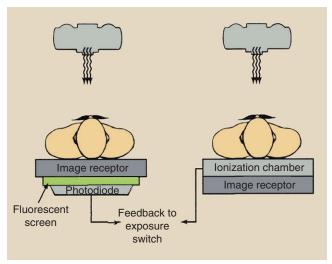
Automatic exposure control terminates the x-ray exposure at the desired film optical density. This is done with an ionization chamber or a photodiode detector assembly.
